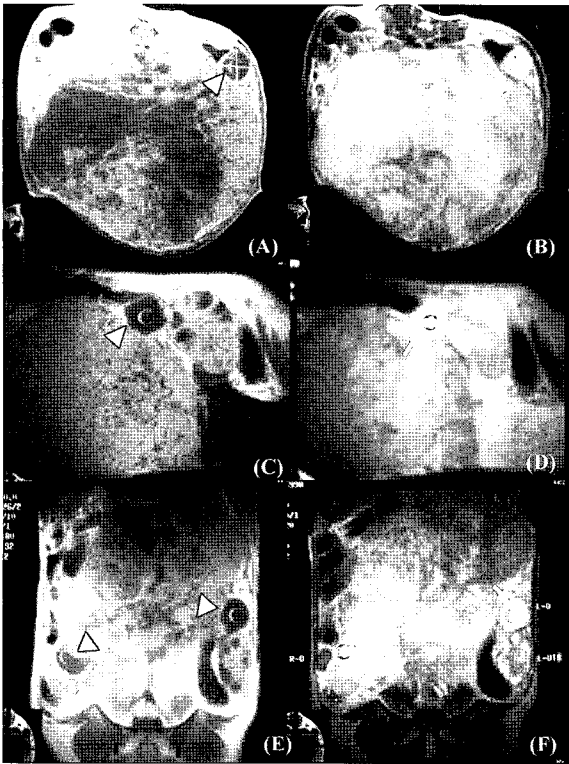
MR images of the abdomen. (A) and (B): transverse view; (C) and (D); sagittal view; (E) and (F); dorsal view. A heterogeneous large mass was observed. On T1-weighted images (WI), hypointensity lesions were found throughout the mass, especially in the central portion (A). Two round hypointensity lesions (arrow heads) were identified at the front and the opposite site of left ovary (A, C, and E). At the same places, hyperintensity lesions (arrows) were found on T2-WI (B, D, and F). The caudal portion of mass closely adjoined the left ovary (C-F). The left ovary was mildly enlarged, and had T1 hypointensity (C) and T2 hyperintensity lesions (D). C: cyst; M: mass; LO: left ovary; RO: right ovary.
